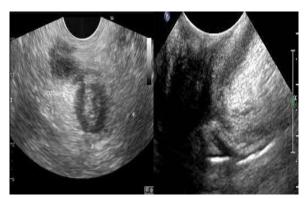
Ultrasonography of pelvic before second operation
